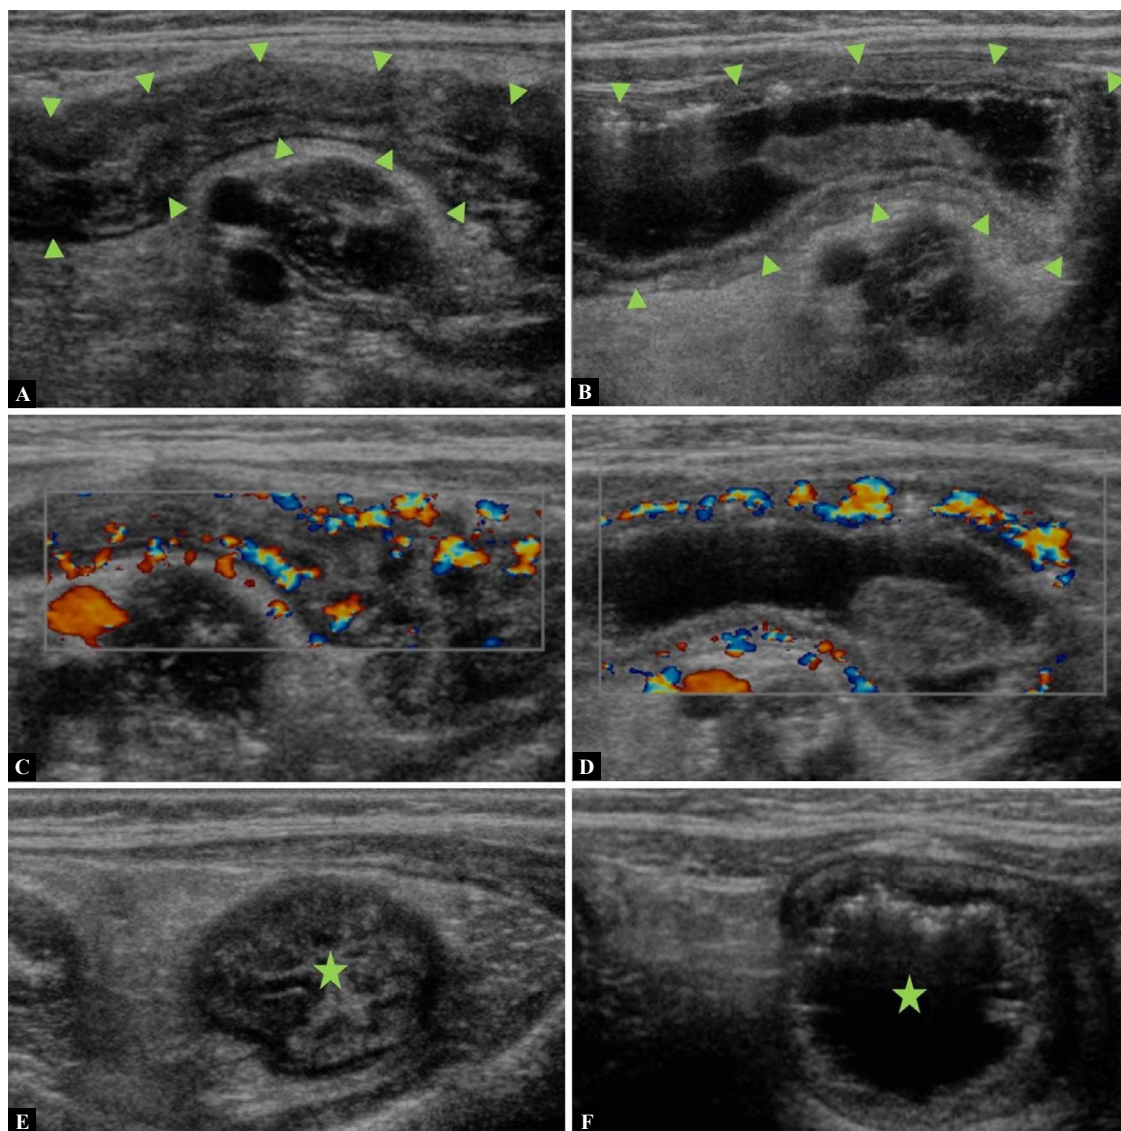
3-year-old boy presenting with hematochezia. Baseline sonography (A, C, E) showed collapsed thickened bowel loops (A: arrowheads, E: star) with marked hyperemia of the bowel wall (C, D). After US enema, the fluid-filled bowel loops enabled a closer evaluation of bowel wall structures (B, D, F). Further diagnostic work-up confirmed the suspected diagnosis of very early onset inflammatory bowel disease
